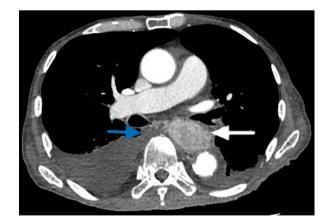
Contrast-enhanced chest computed tomography (axial view, white arrow) showed a tumor measuring 9.8 × 4.1 × 2.1 cm in the middle to lower thoracic esophagus with enlarged paraesophageal and subcarinal lymph nodes (blue arrow).
